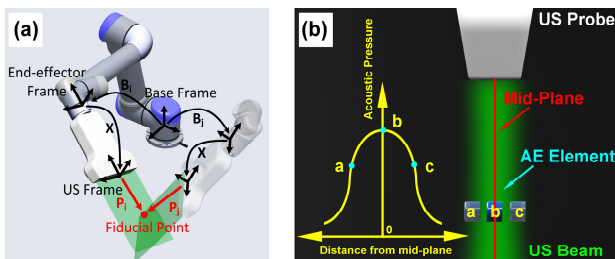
a) The coordinate transformation in the BXp calibration using a robotic arm as the tracking system. The US probe is attached to the arm, and the B_i is measured from the robot encoders. b) Using AE element for the mid-plane localization. At position b , AE element receives the maximum ultrasound signal amplitude. At a and c , although the element is still shown US image, the received signal amplitude is lower compared to b .
